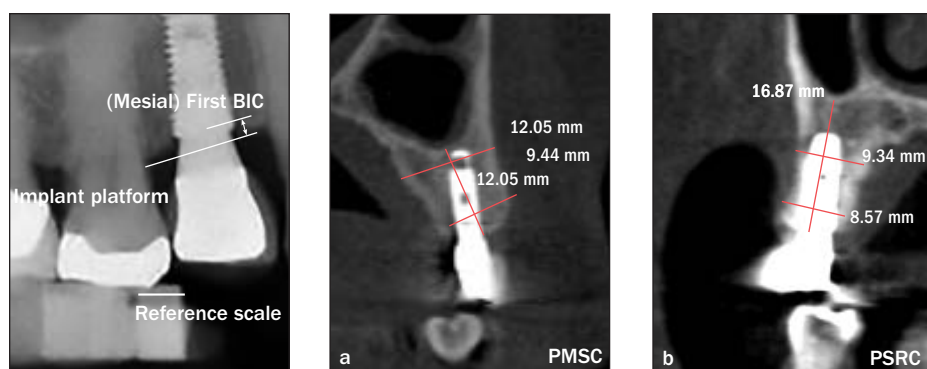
(far left) Radiographic assessments of marginal bone level (MBL) changes. MBL was defined as the vertical distance between the first radiographic bone-implant contact (BIC) and the implant platform.
